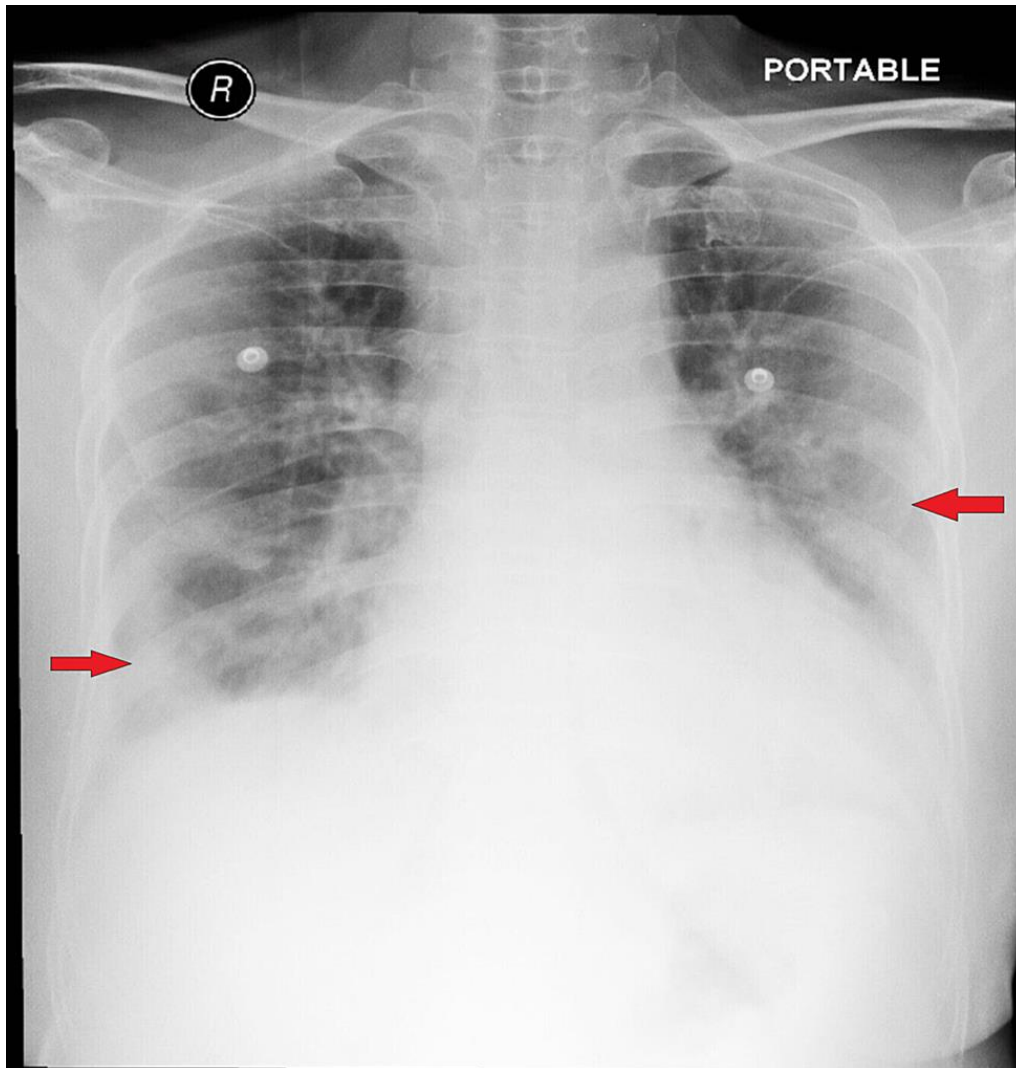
Portable chest x-ray of the patient on the day of hospital admission, showing ill-defined opacities and fibro-linear strands in bilateral lung fields (red arrows).
